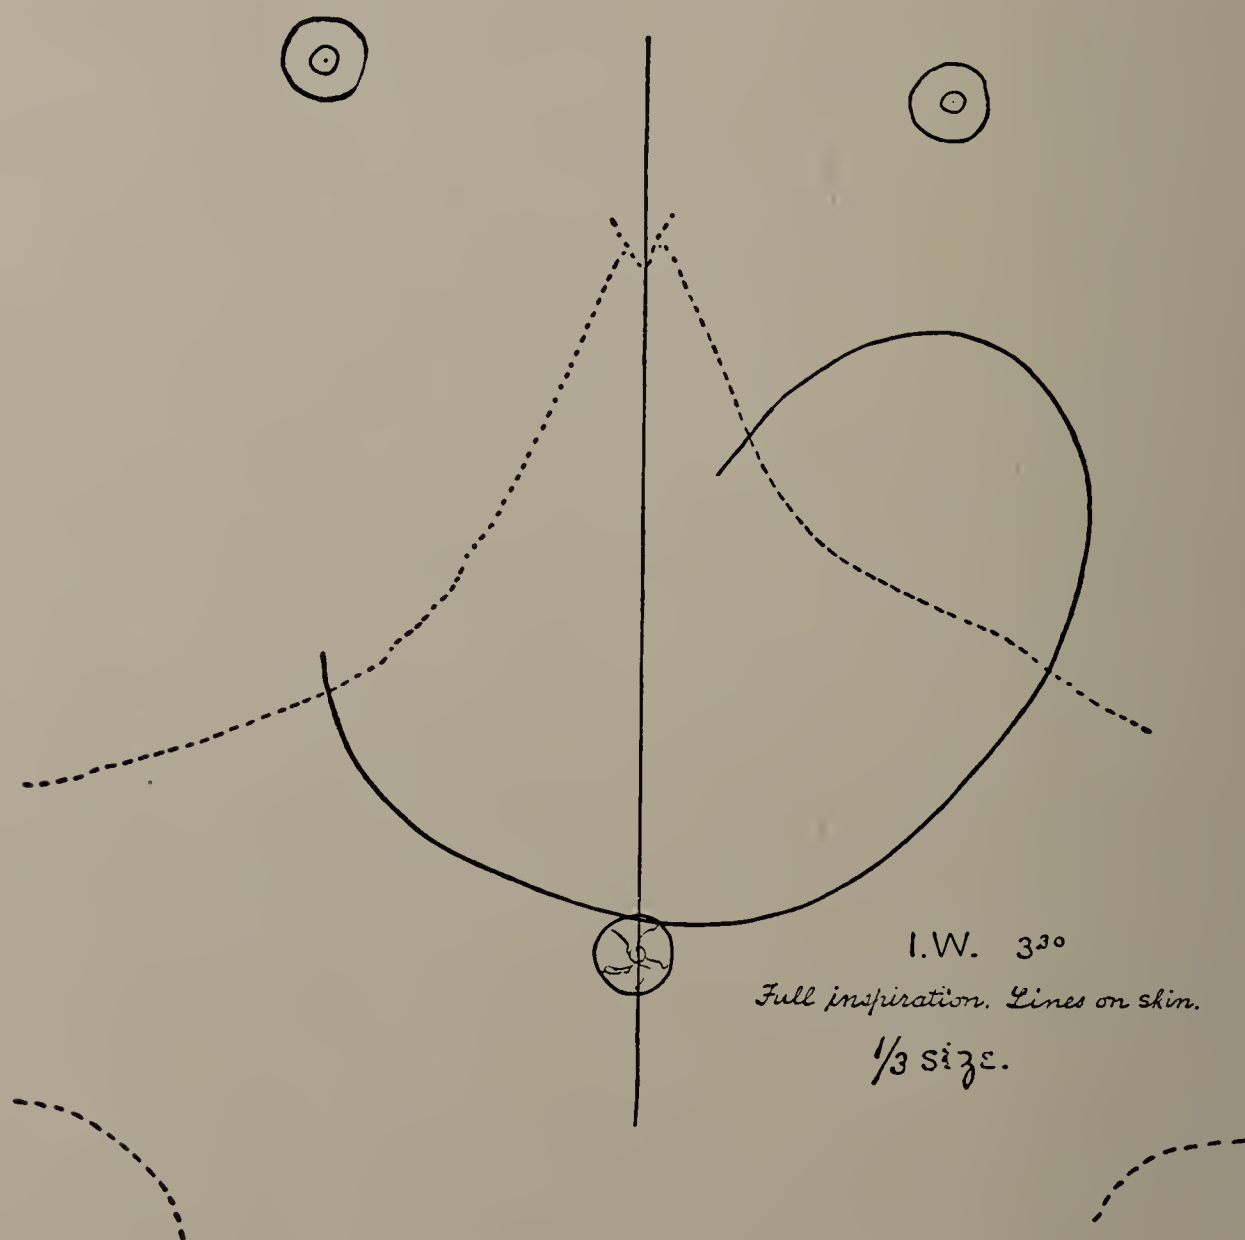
James W. Cut of X-ray tracing. 3.30 P.M. In order to show the position of the nipples, the costal borders, and the iliac crests, this tracing was reduced to one-third its original size.
